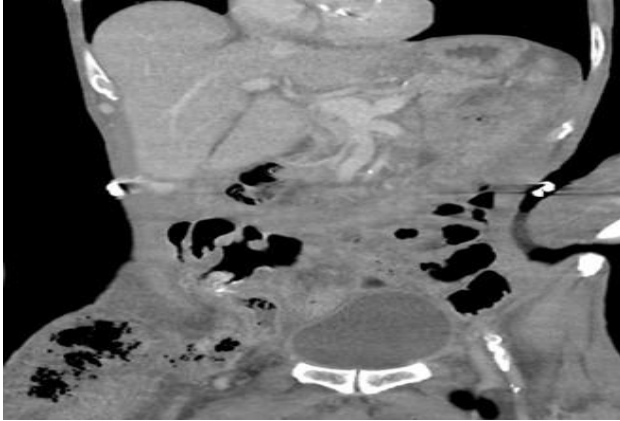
A coronal CT image of the femoral hernia and subcutaneous emphysema of the right thigh.
